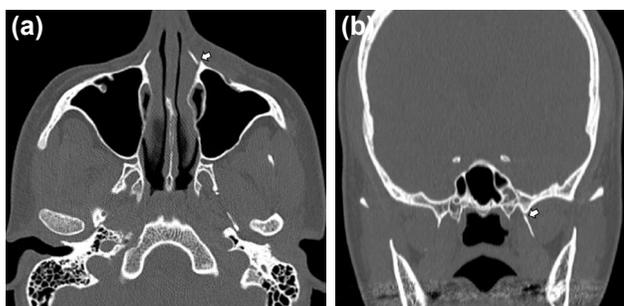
A 17-year-old man with nasal fracture. Axial CT image (a) reveals fracture of the left nasal process of the maxilla (arrow). The left pterygoid plate is also fractured (arrow) on coronal CT image (b).
